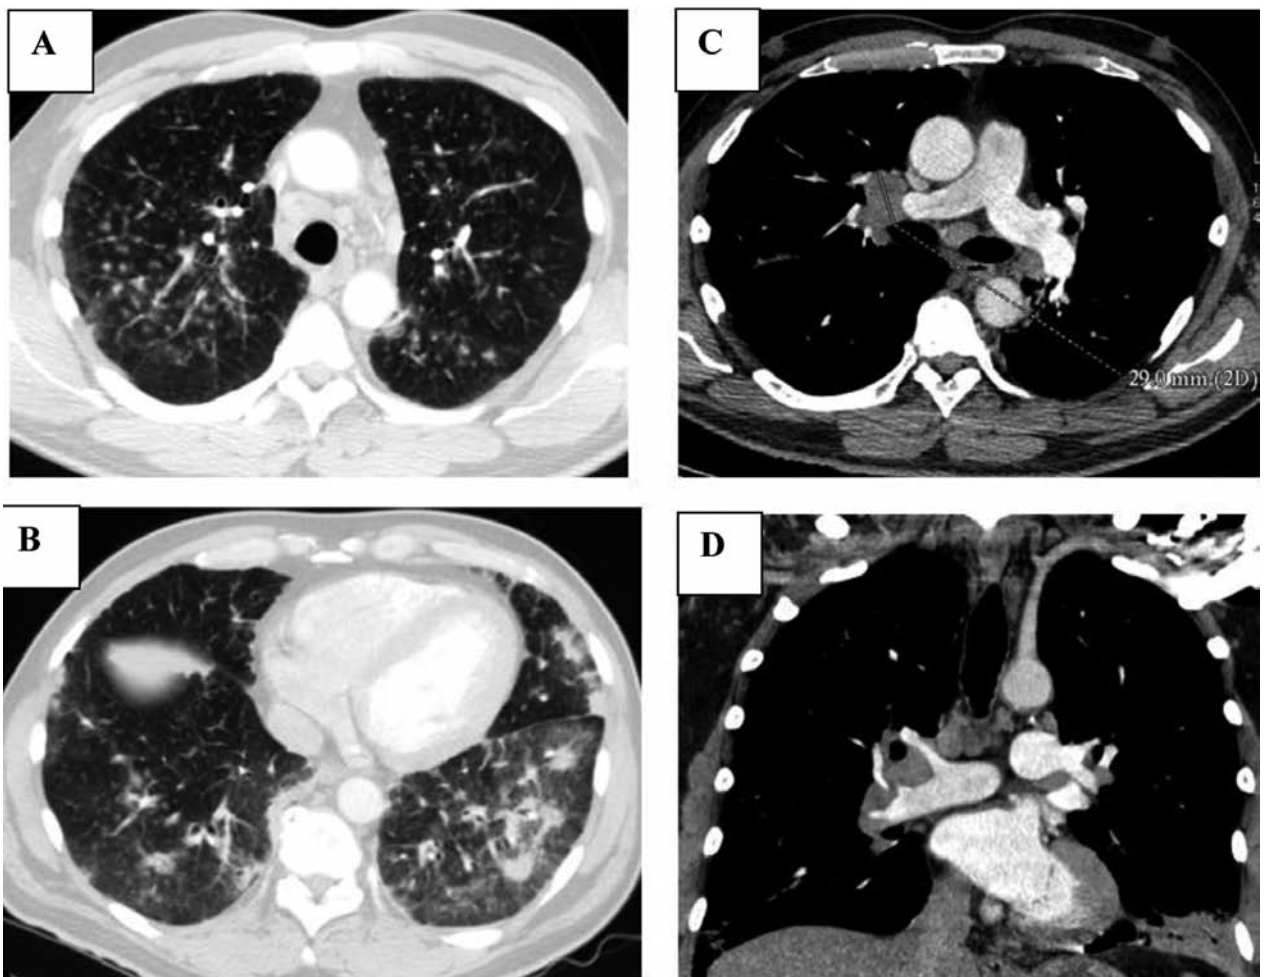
Chest CT showing (A) micronodules in upper lobes (B) ground glass pattern, condensations and thickening of peribronchovascular bundles (C-D) interbronchial and mediastinal lymph node enlargement
